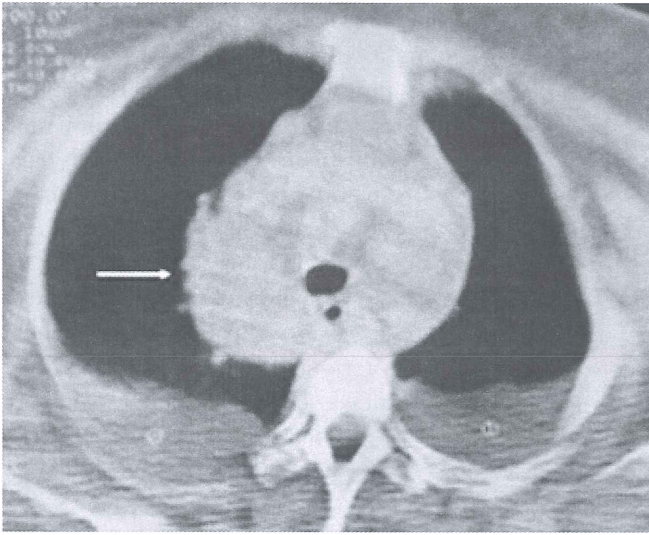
Thorax CT revealed a heterogeneous round mass which contained necrotic areas. The widest (arrow) diameter of the conglomerated mass was 15 cm. Note the mild to moderate pleural effusion in both hemithoraces.
